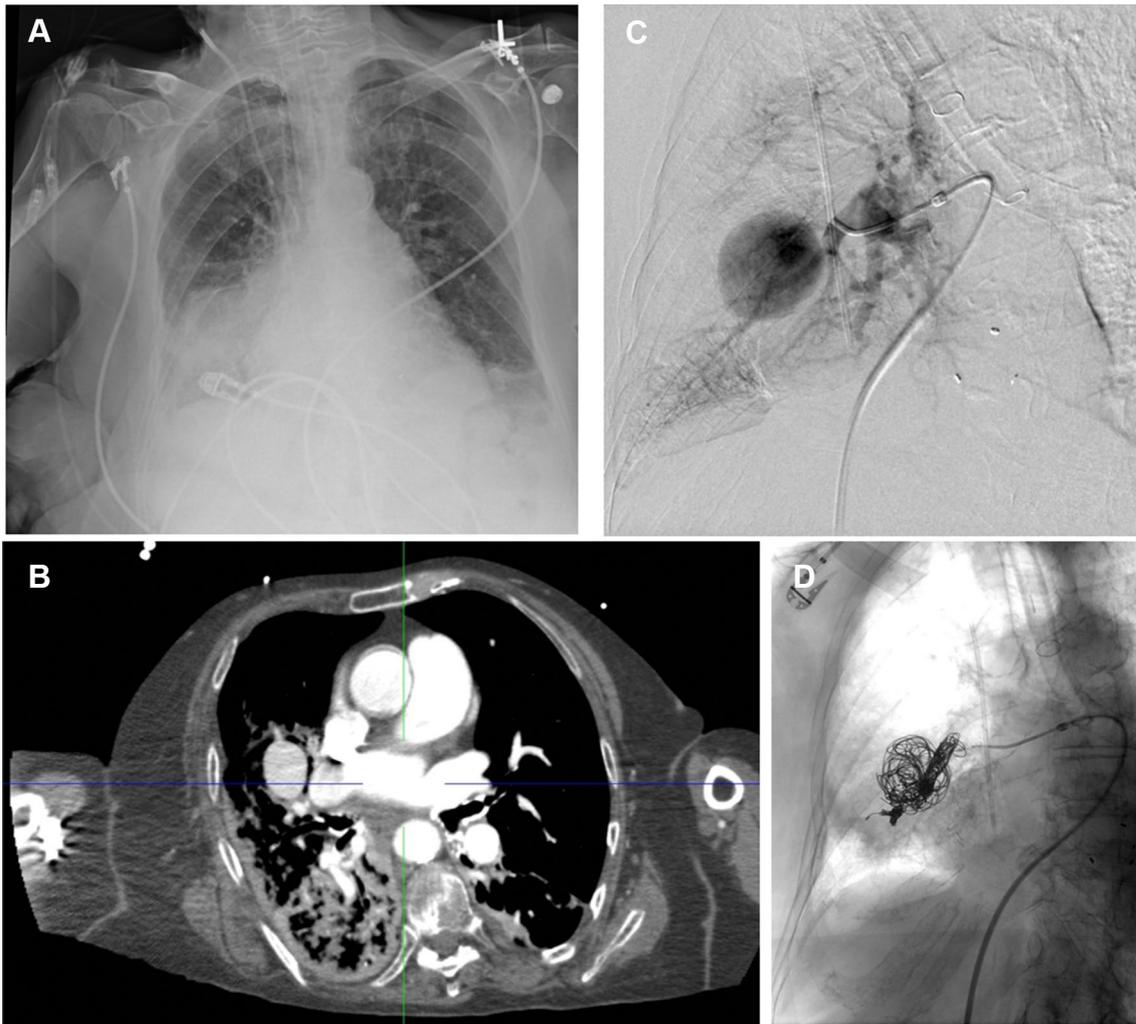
Imaging of a 75-year old woman with pulmonary aneurysm that necessitated coil embolization. a Chest X-ray does not clearly demonstrate the aneurysm. b CT with contrast clearly demonstrates
